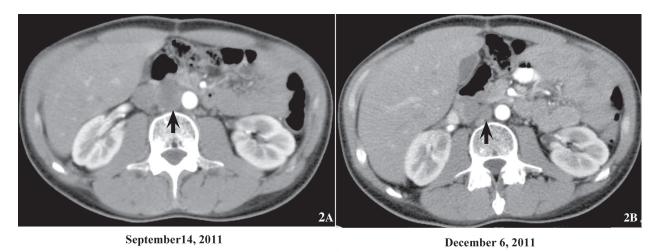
CT Upper abdomen at level renal hilum, before treatment (2A) and after 2 courses of treatment (2B).
